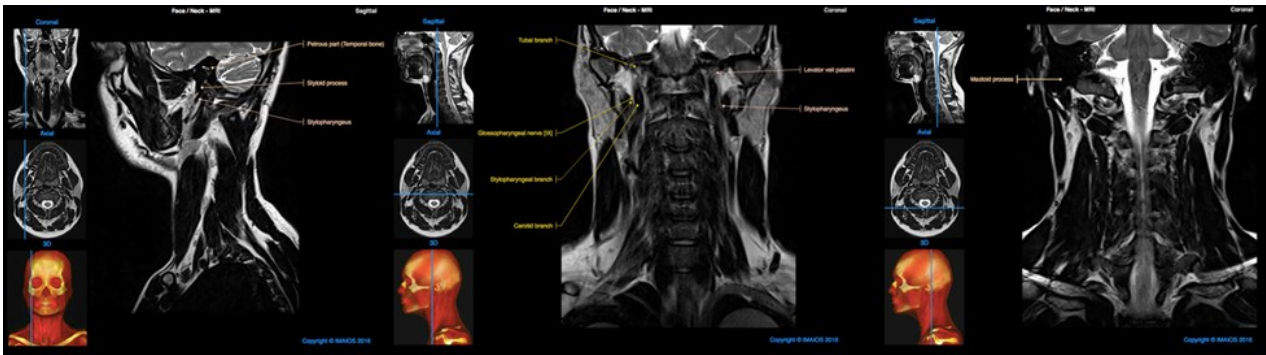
T2 MRI images of the mastoid process, styloid process and glossopharyngeal nerve branches. Images obtained by permission from IMAOS.com (Montpellier, France).
